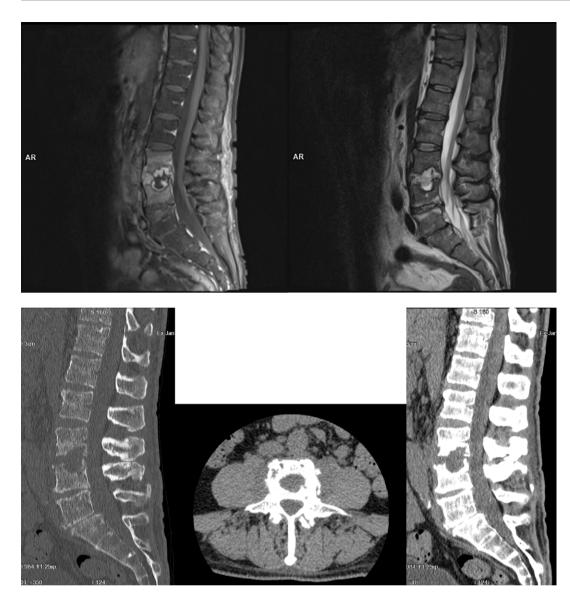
Magnetic resonance imaging (MRI) of the lumbar spine . T1-weighted (Left) and T2-weighted (Right) sagittal images after contrast administration showing destruction of the L3 and L4 vertebral bodies, widening of the L3/L4 intervertebral space and inflammatory changes in the perivertebral soft tissues.
